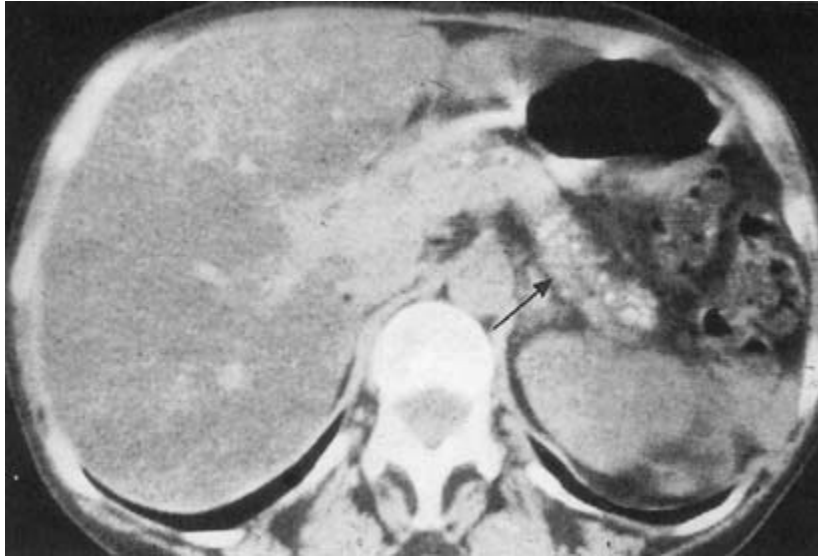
CT scan showing an enlarged fatty liver with a chronic calcific pancreatitis (arrowed).
